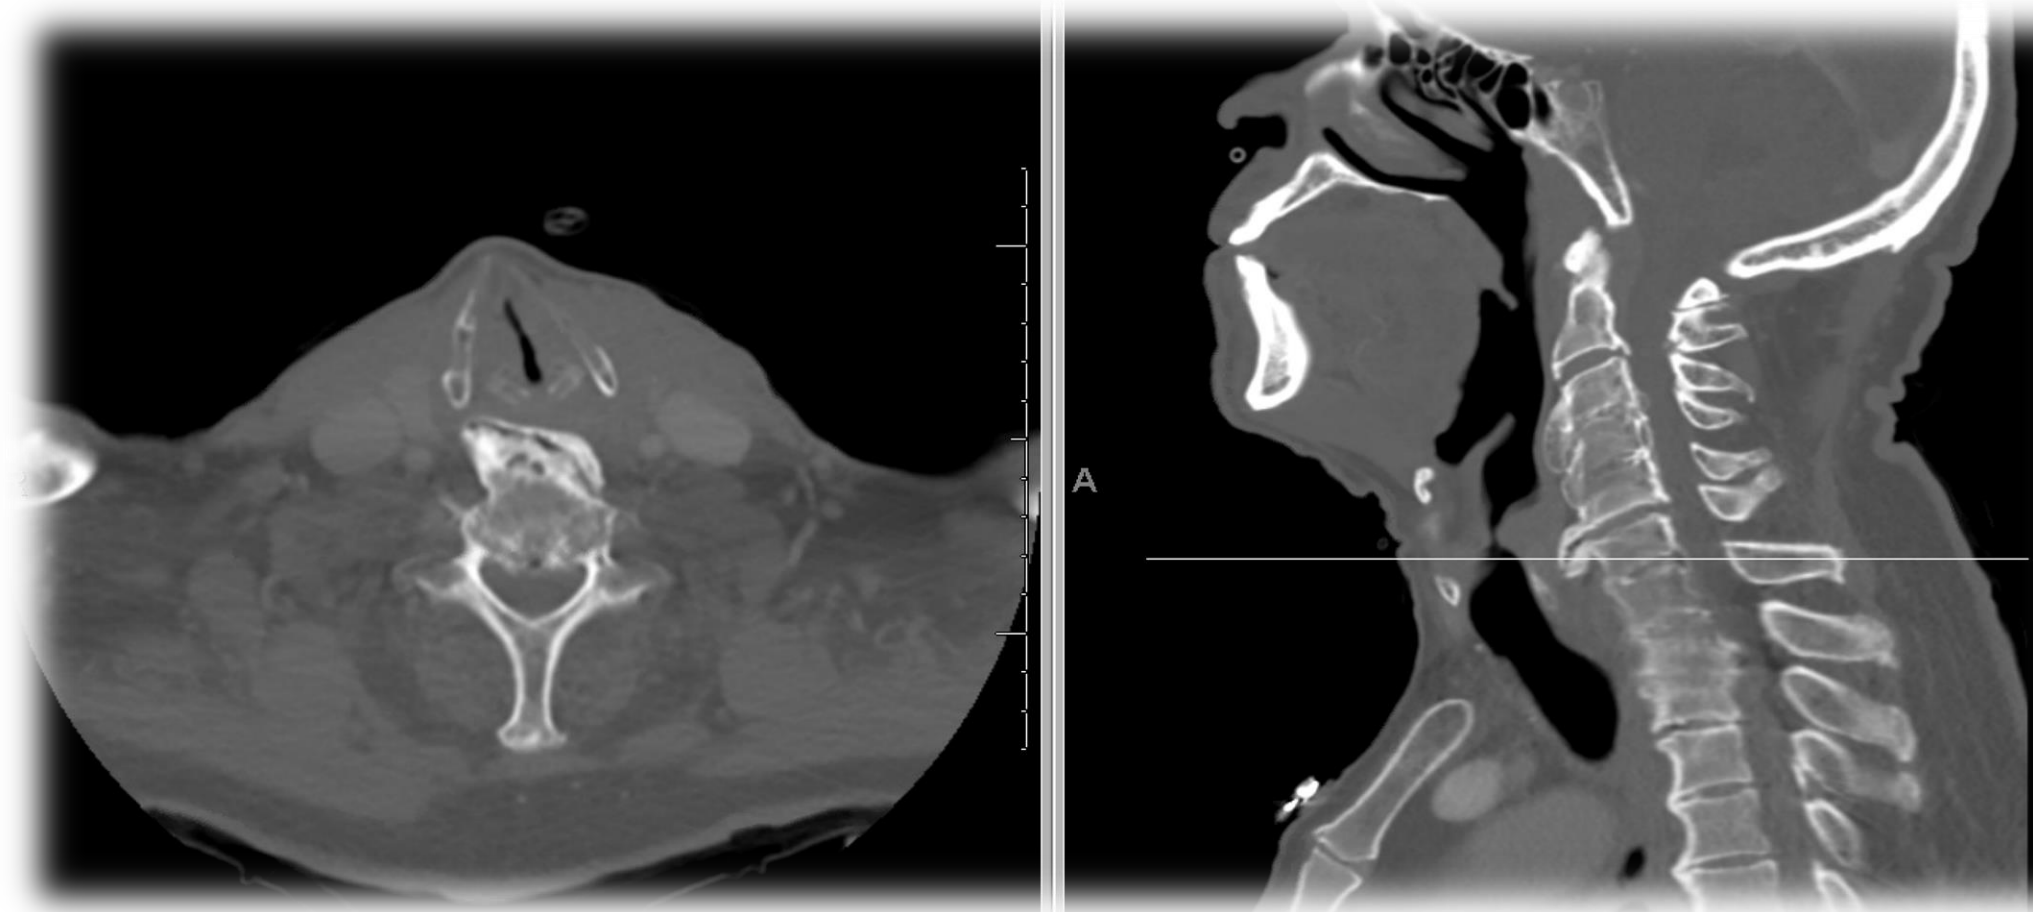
CT axial and sagittal, respectively, of cervical spine two years prior to surgical intervention
